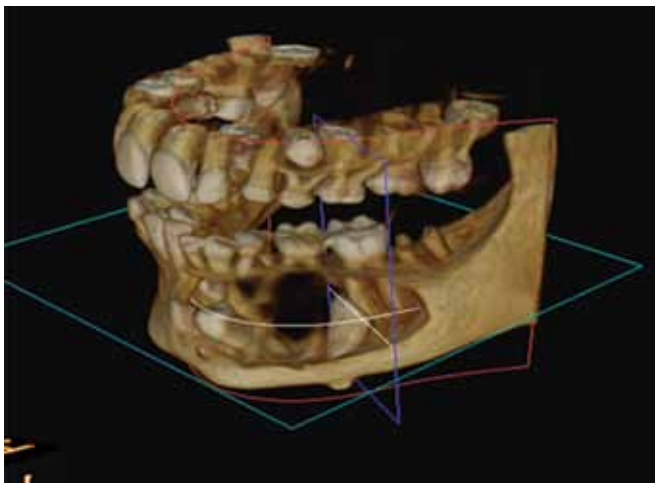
Three-dimensional view of CBCT
